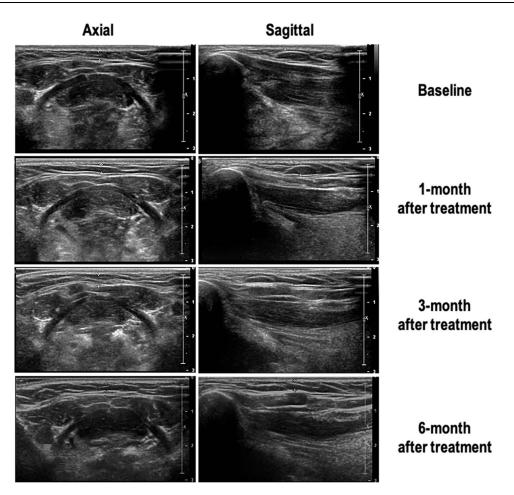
Ultrasound images (2 dimensions) of the representative patient.
